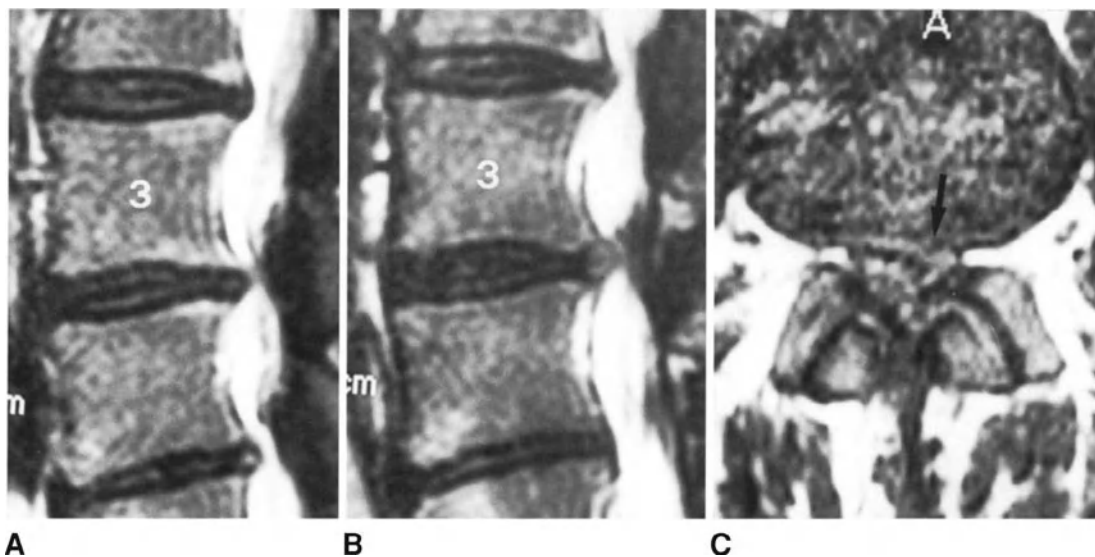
Constitutional canal stenosis of the spinal canal and disc herniation. (A) and (B) Spin-echo T2-weighted sagittal MR images revealing moderate stenosis at L2-L3 and L4-L5 levels and marked stenosis at L3-L4 level. (C) Spin-echo T1-weighted axial MR image at L3-L4 level showing disc herniation on the left.
